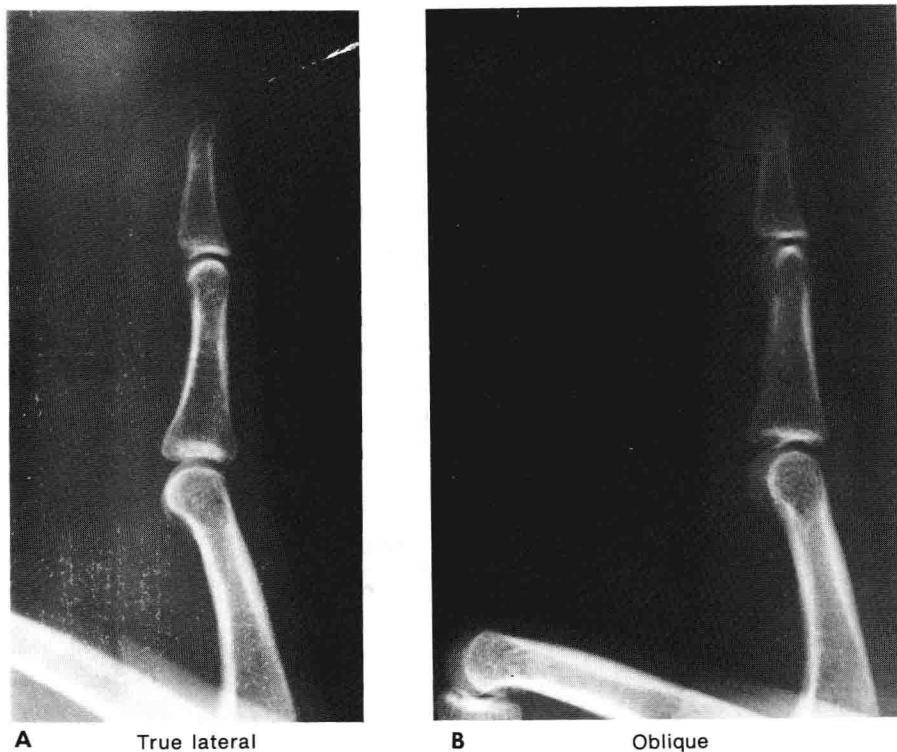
Use the Fingernail as a Landmark. The fingernail is a perfect external landmark for obtaining a true lateral of the bone of the digit. If a true lateral x-ray of the fingernail is obtained, a true lateral x-ray of the underlying bones is sure to follow.
